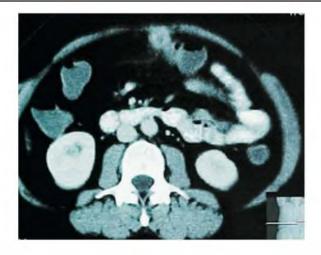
CT scan of the second patient showing mass adherent to the anterior abdominal wall in midline.
